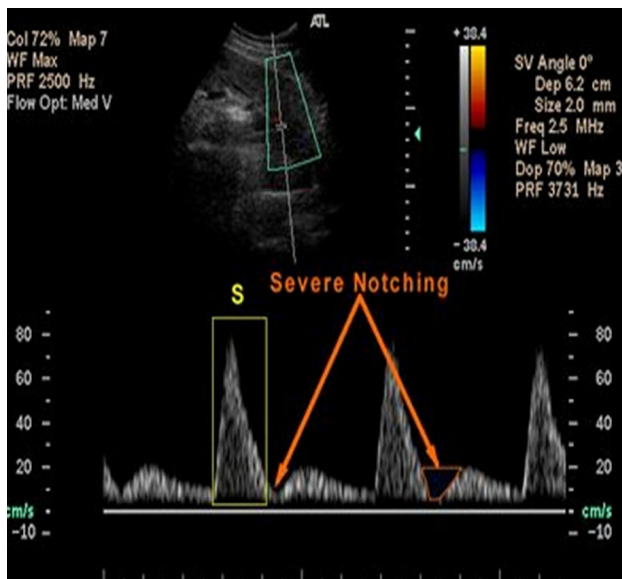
Uterine artery Doppler in FGR with abnormal resistance
